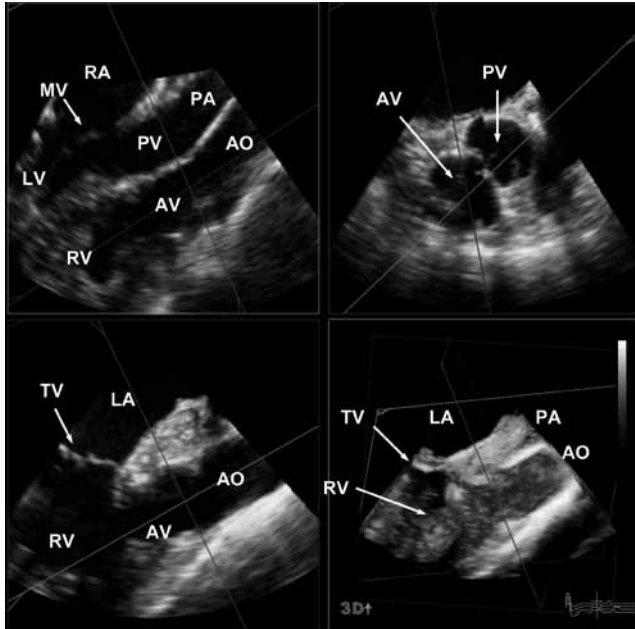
Transesophageal RT3DE dataset with multipane representation in the same patient with congenital corrected TGA shown in Figure 22 with clear demonstration of the abnormal, parallel orientation of the aorta (AO) and aortic valve (AV) to the pulmonary artery (PA) and pulmonary valve (PV) (top left). LV left ventricle, RV right ventricle, RA right atrium, LA left atrium, MV mitral valve, TV tricuspid valve.
